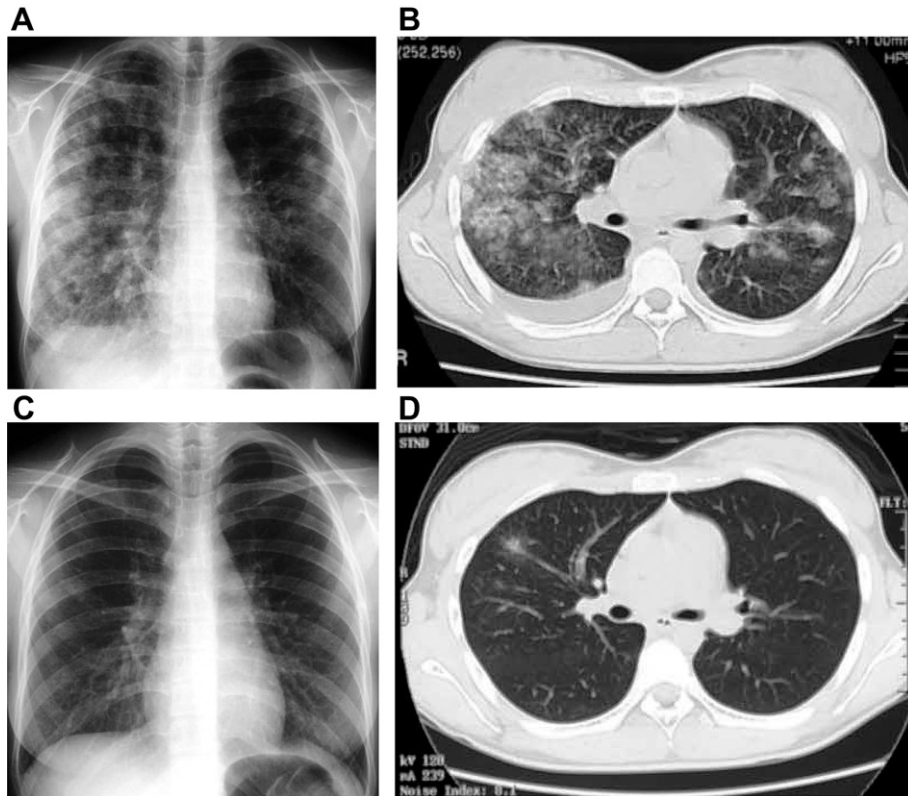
Chest X-rays and CT scans. A. The chest X-ray on admission showed bilateral ground-glass opacification which was relatively right lung dominant. B. A chest CT on admission showed diffuse ground-glass opacification in the right lung, patchy opacification in the left lung, and a small amount of pleural effusion in the right lung, consistent with the opacification on chest X-ray. C. A chest X-ray on the seventh hospital day showed subtle opacification, indicating remarkable improvement. D. A chest CT scan taken on the 12th hospital day showed decreases in the patchy infiltrates.
